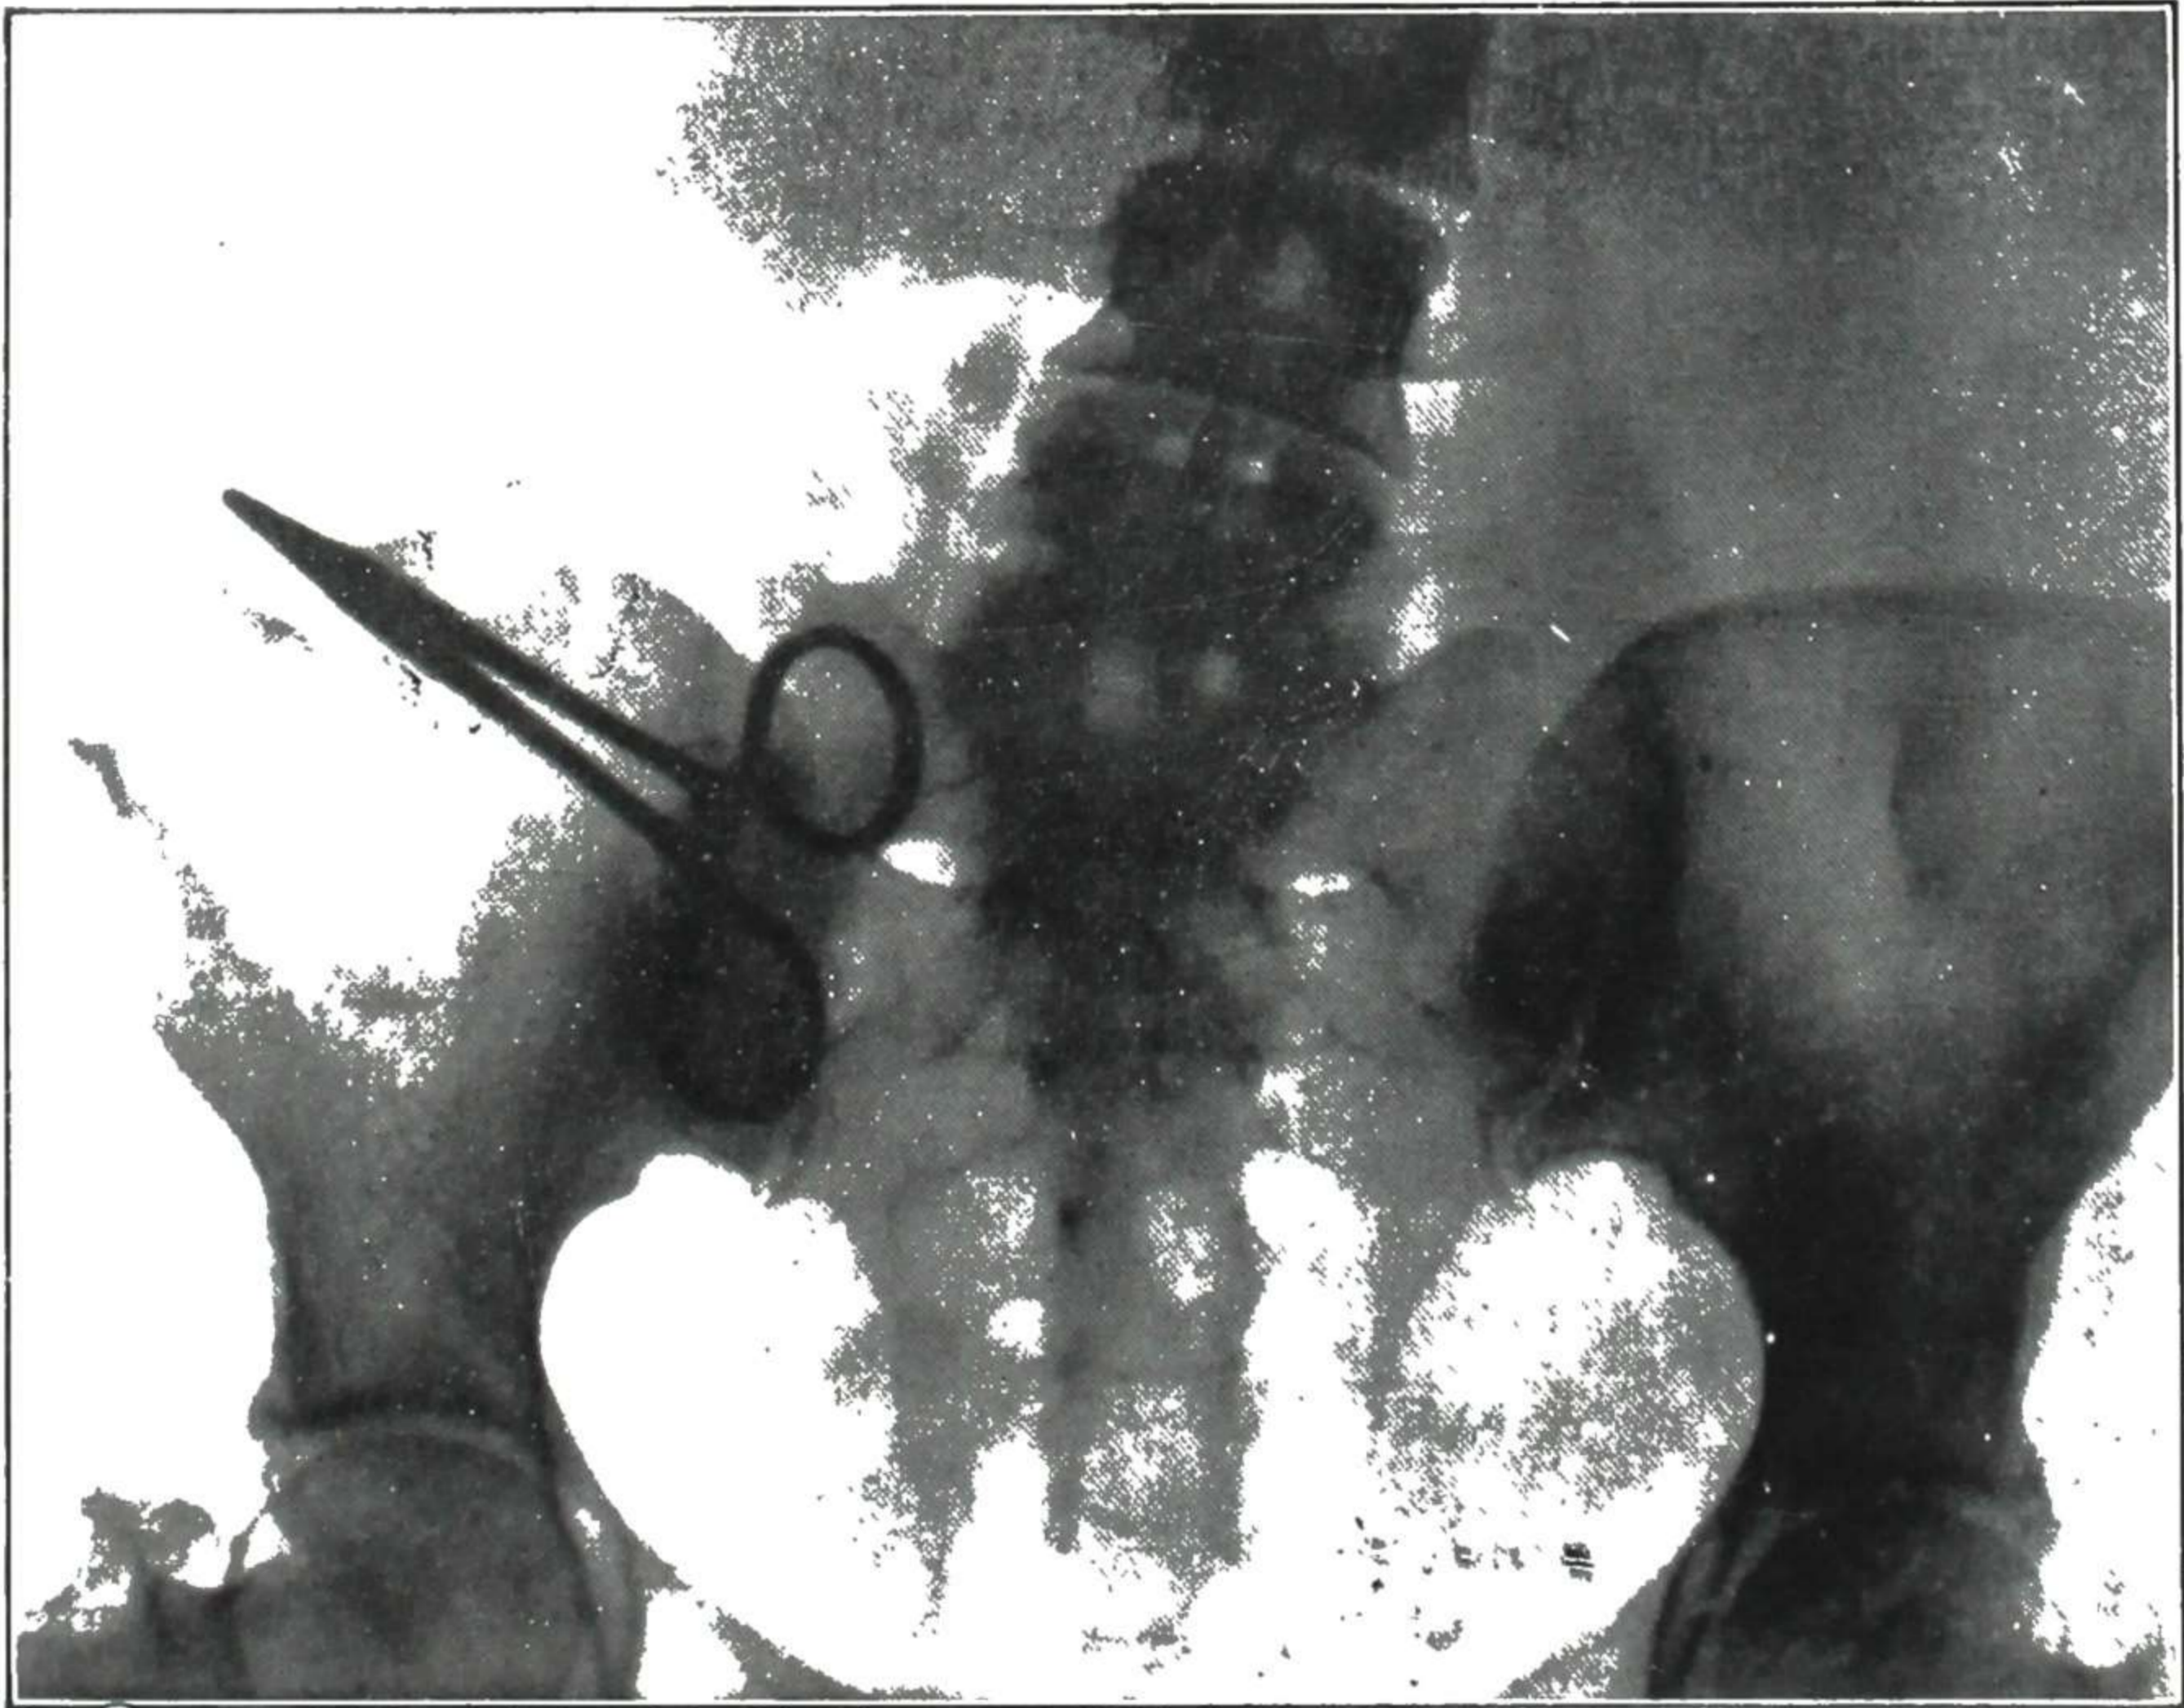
X-ray film showing a forceps (hemostat) in the abdomen four years after an abdominal operation. The patient was supposed to have a tumor, till x-ray examination revealed the forceps.
